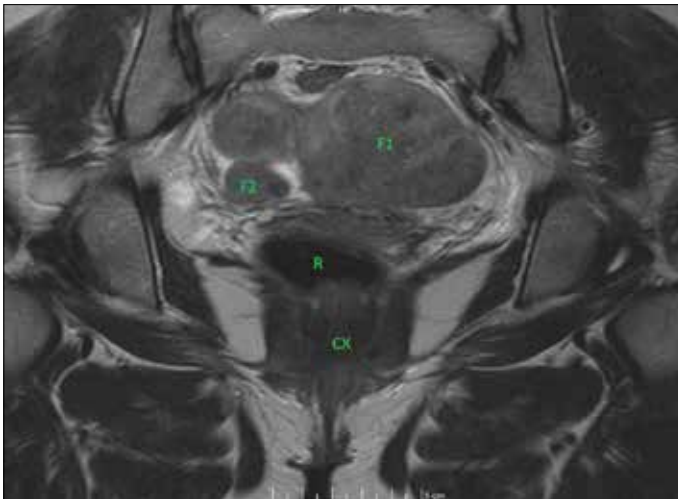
MRI showing a smaller fibroid 2.7×2×3 cm (F2) above the cervix (CX) in addition to the larger fibroid (F1)
